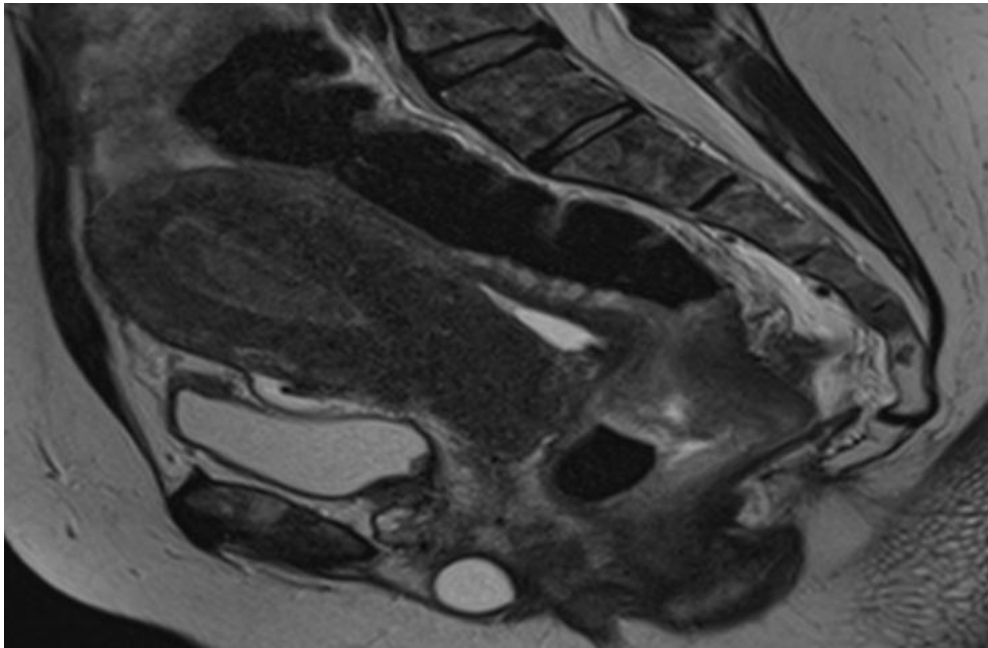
MRI pelvis T2 sagittal view showing diffuse T2 hypo intensity of the cervical stroma with loss of zonal anatomy (thick arrow). Diffuse thickening of the junctional zone. There is a circumferential mass seen in the rectum (arrow). Mild ascites with T2 hypo intense nodular thickening of the peritoneal reflection, dome of the urinary bladder (star). Heterogeneous signal of the bone marrow. Gartner duct cyst is seen *
